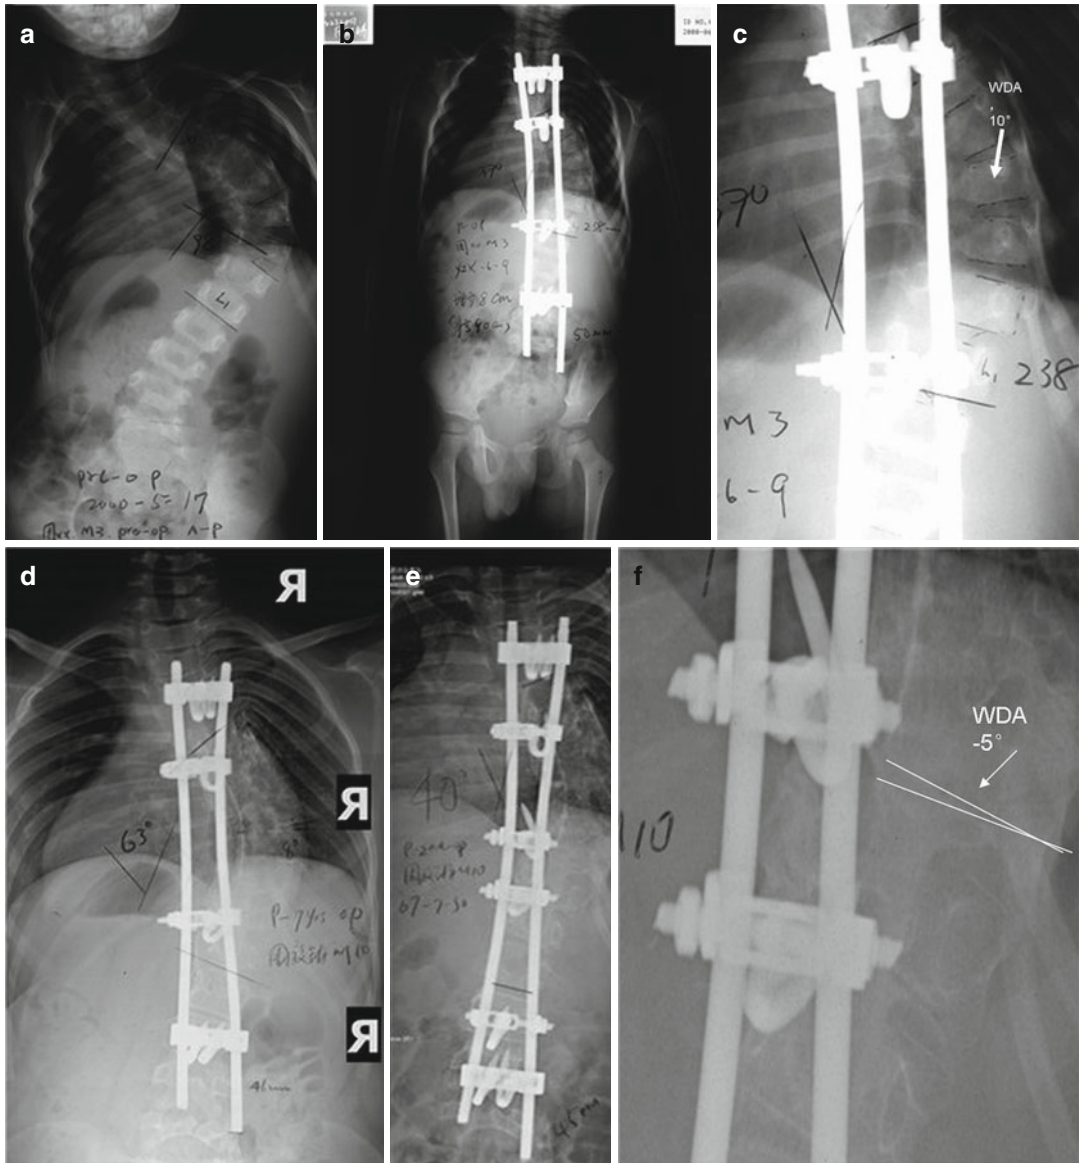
Zu xx, a 3-year-old boy with scoliotic curve of 98° (a), post-op scoliotic curve was 37° (b). The WDA was 10° (c; see arrow). Seven years after operation, the scoliotic curve was 63° (d). After second operation, scoliotic curve was reduced to 40° (e). WDA was reduced to -5° (see arrow). (f) X-ray showed bony fusion on convex
